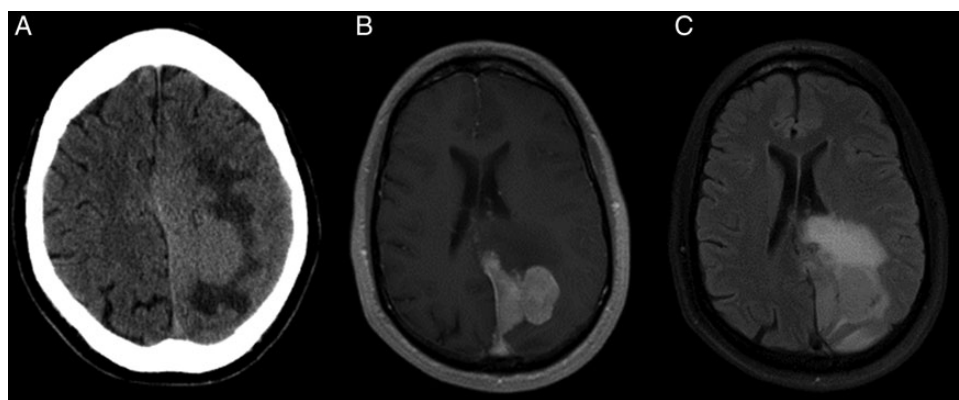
(A) Unenhanced CT, (B) Postgadolinium spin echo T1-weighted, and (C) T2-weighted FLAIR images depict a relatively circumscribed mass impressed into the left superior temporal lobe with both solid, enhancing components and some cystic or necrotic areas. Moderate edema signal surrounds a portion of the mass.
